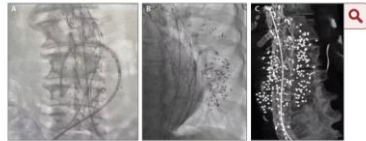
Intraoperative image of SMP deployment mid-fill (A). Intraoperative image of SMP deployment post fill (B). Postoperative CTA (C).
